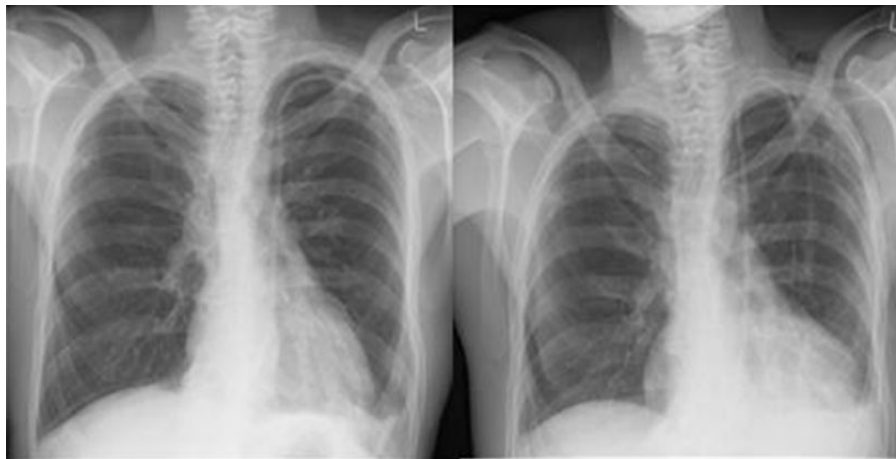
Chest X-ray postero-anterior view (on the left) demonstrating the dialysis catheter in the left hemithorax and (on the right) demonstrating cardiomegaly, left-sided pleural effusion and left-sided surgical emphysema.
